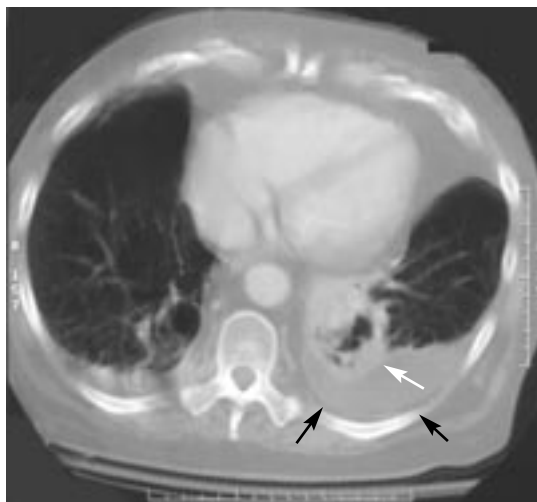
Computed tomographic scan showing cavitating retrocardiac infiltrate (white arrow) with adjacent pleural effusion (black arrows).
